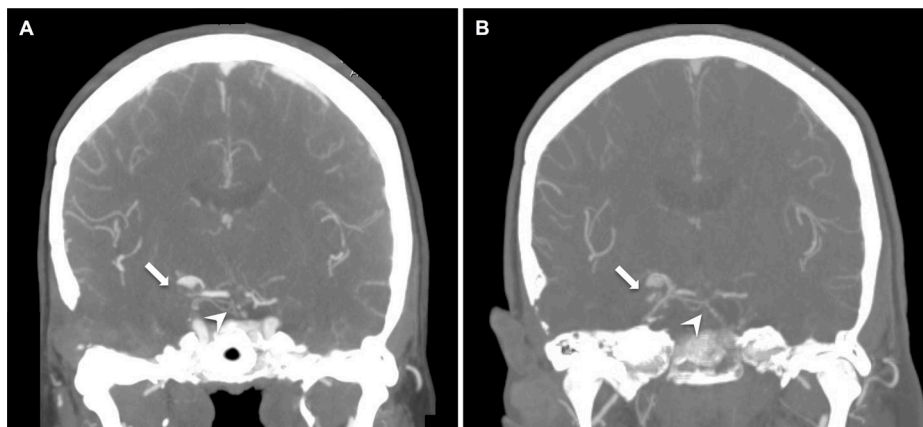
Postoperative imaging. (A) On postoperative day 4, coronal CTA showed flow through the basilar (white arrowhead) but absent filling of the graft (white arrow). (B) At most recent postoperative follow-up (15 months), the basilar artery remained patent while the graft failed to demonstrate flow.
